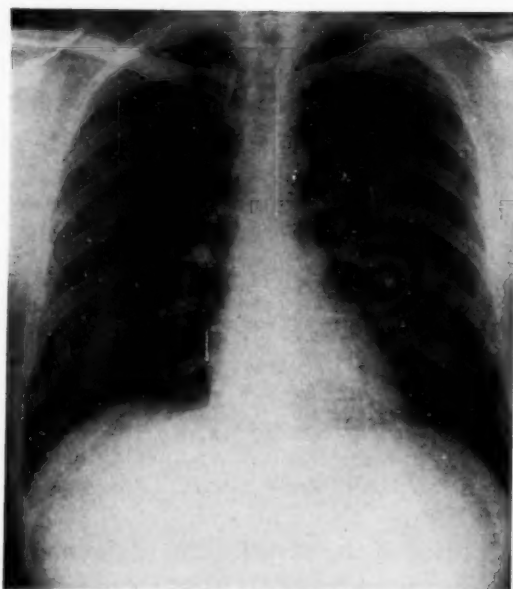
Chest x-ray demonstrating pulmonary calcifications of histoplasmosis of patient.
